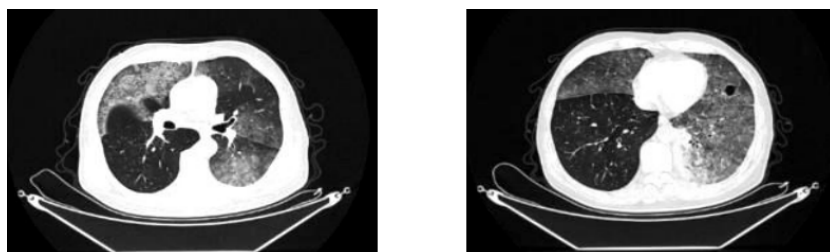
Chest CT performed on October 14, 2024
